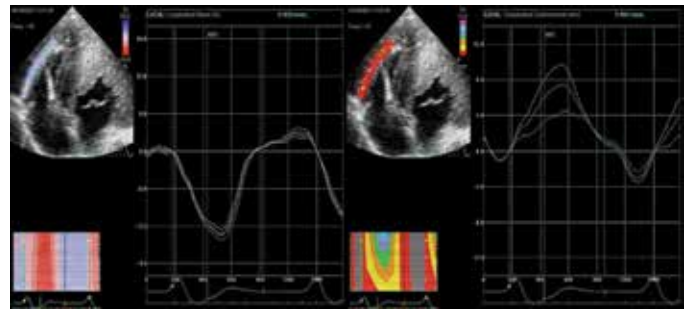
Right ventricular free wall longitudinal strain and displacement by 2D speckle tracking echocardiograph.
